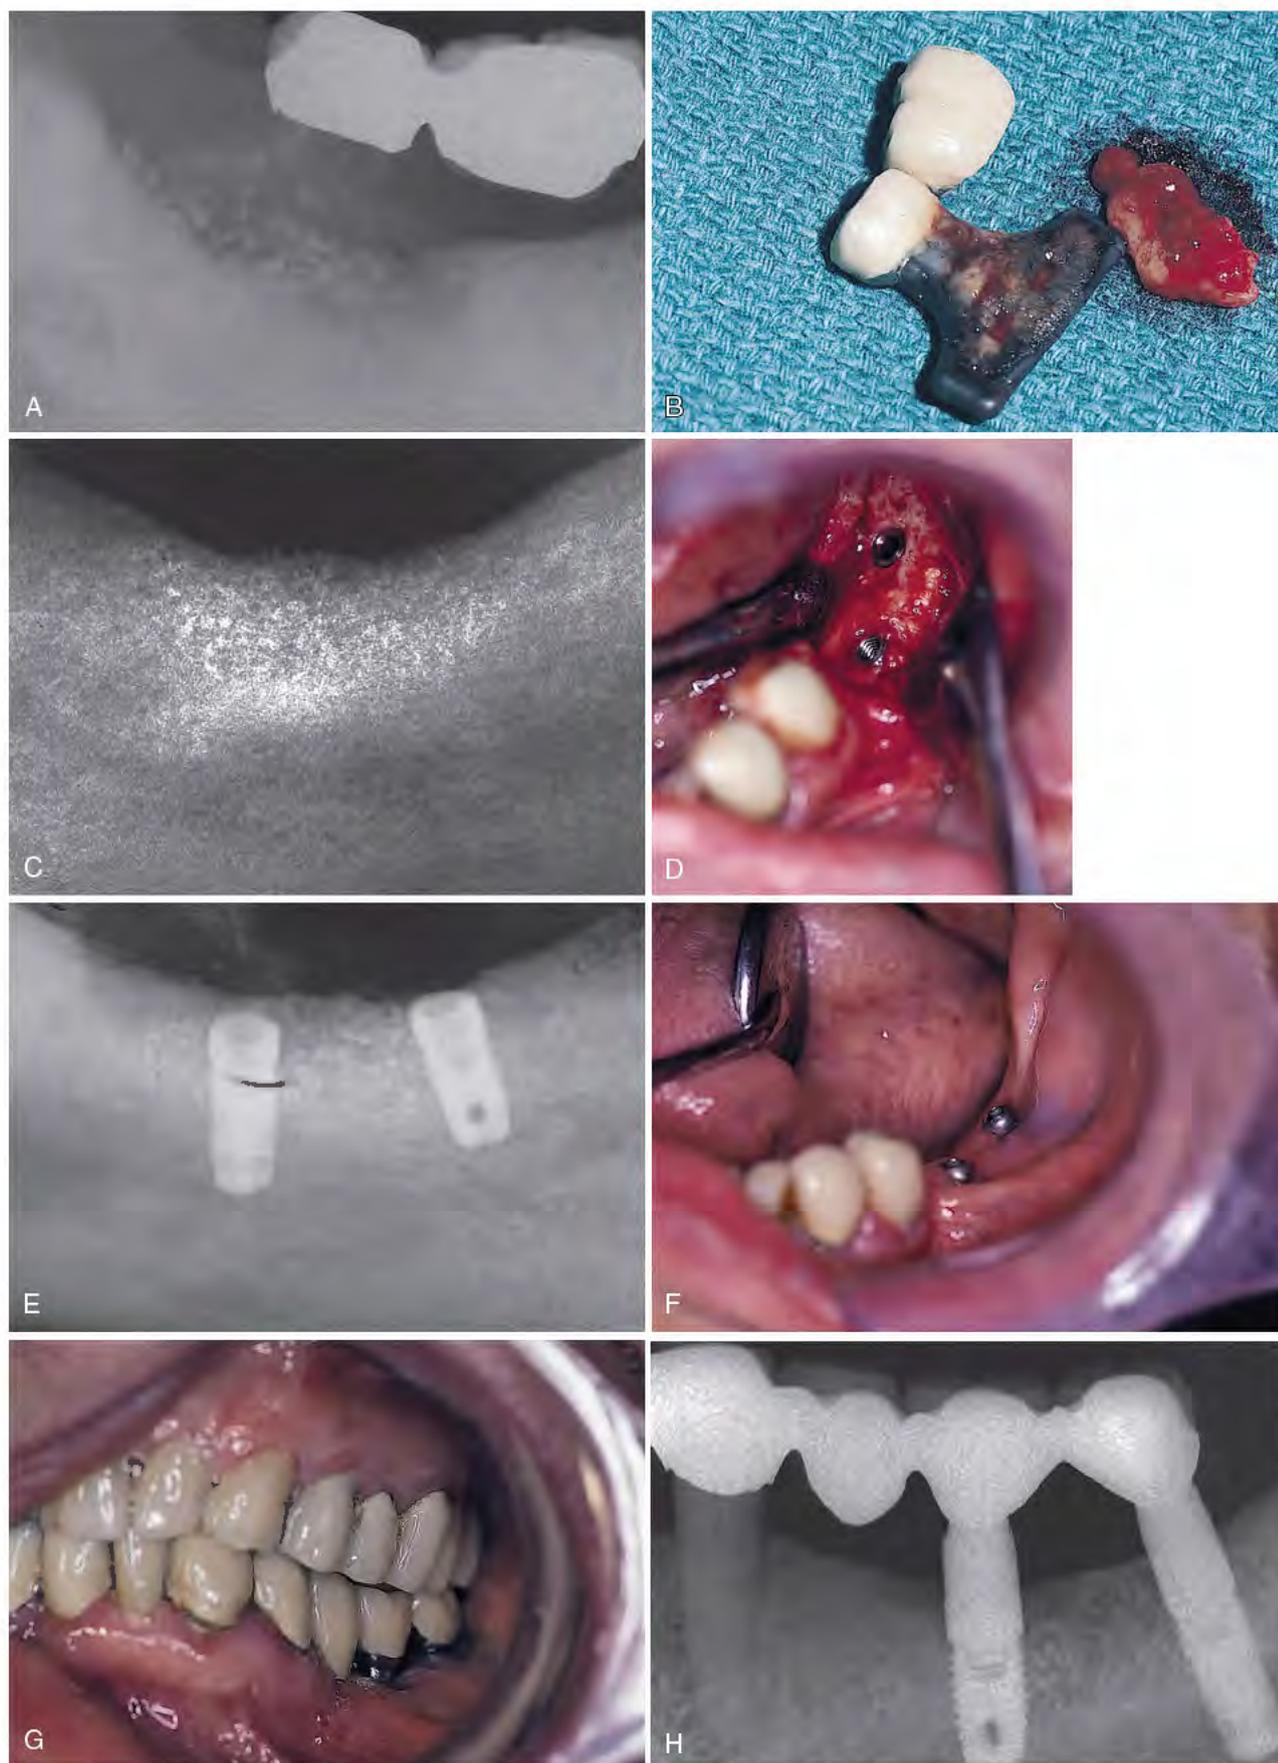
A, A radiograph of a failing, radiolucent, carbon blade implant shows a large, round, lytic host site. B, Granulomas are the lesions that most commonly surround such failing endosteal implants. To restore the area, thorough curettage must be incorporated into the operative plan. C, The host site may be grafted (hard tissue replacement [HTR] and Osteogen) only after complete debridement. D, Nine months later, replacement root form implants may be inserted. E, The resulting well-ossified host site supports the new implants. F, Six months are required to ensure osseointegration. At that time, second-stage surgery allows placement of healing collars. Periotest scores indicate true bony support. G and H, The clinical and radiographic appearances of this restored mandibular left quadrant demonstrate a firm, fixed prosthesis that is functioning satisfactorily in its seventh year.
